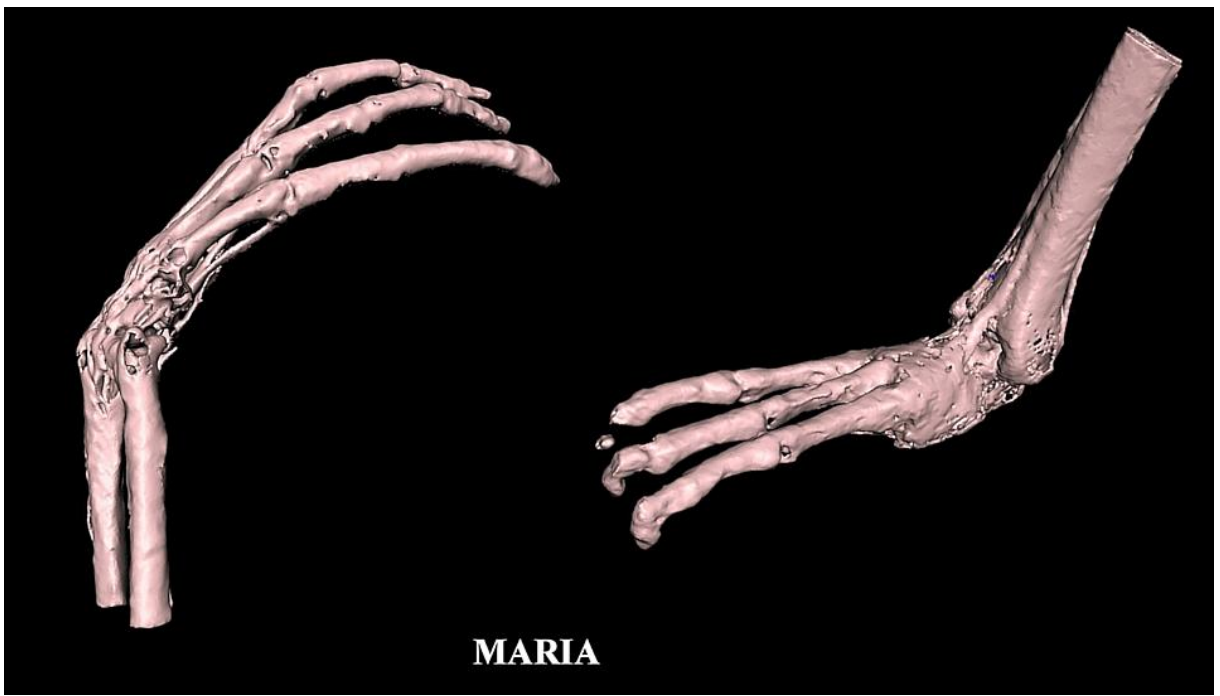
3D CT of right hand (*left*) and right foot (*right*). Note presence of 5 segments in each finger and 4 segments in each toe.
